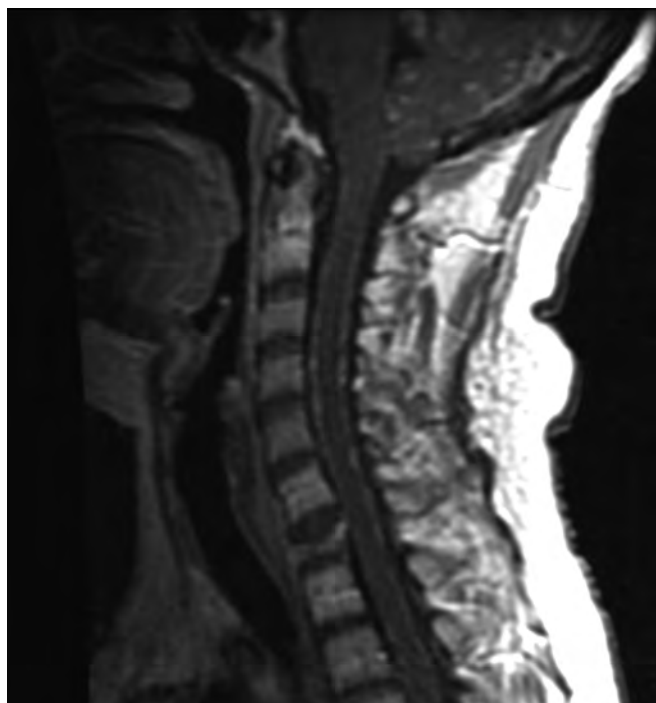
Sagittal gadolinium-enhanced spine magnetic resonance imaging reveals thickening and nodular enhancement of the leptomeninges adjacent to the cervical spinal cord.
